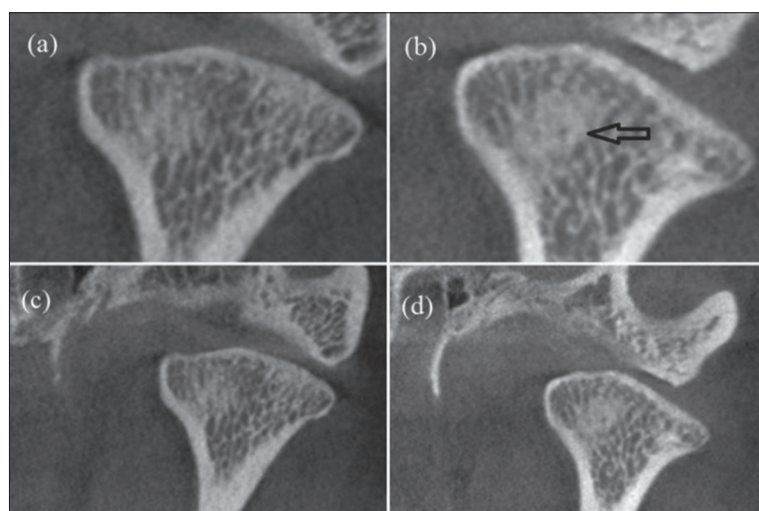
Osteoarthritis changes of the left and right temporomandibular joint (TMJ) on CBCT; the right TMJ without subcortical pseudocyst (a); subcortical pseudocyst of the left TMJ (b); ero-sion of the right (c) and the left (d) TMJ
